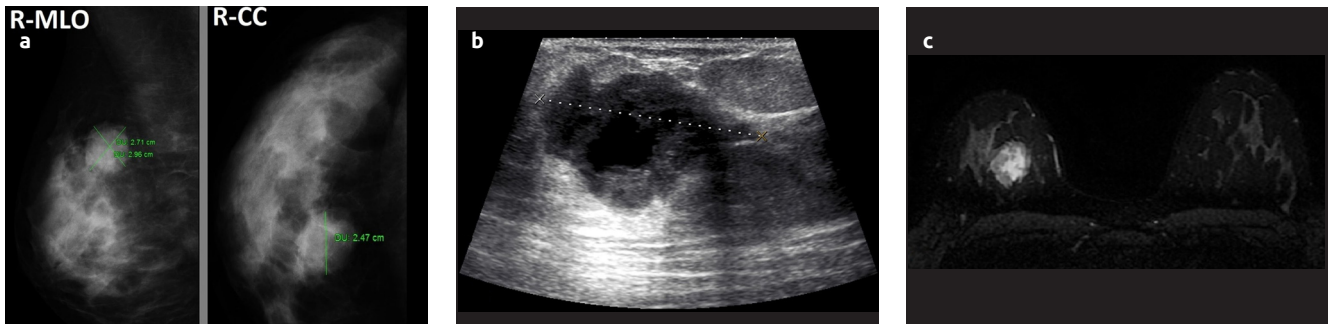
a-c. Imaging findings are shown of a 26-year old patient with grade 3 invasive ductal carcinoma. Mediolateral and craniocaudal mammography images (a) demonstrate round shape, ultrasonography image (b) shows internal heterogeneity and posterior acoustic enhancement and magnetic resonance image (c) indicates T2W hyperintensity
